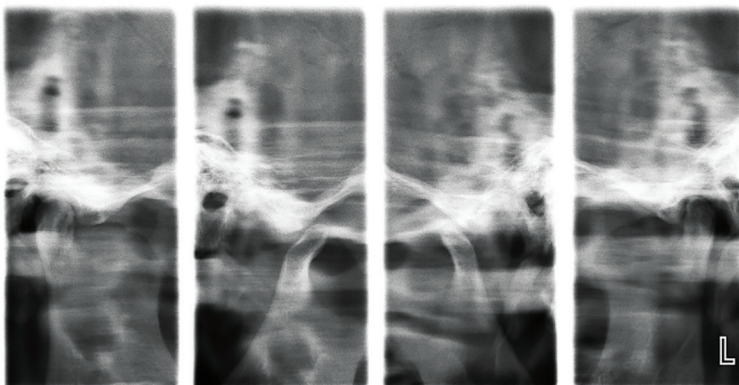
Temporomandibular joint (TMJ) Radiograph: Bilateral Hypermobility
